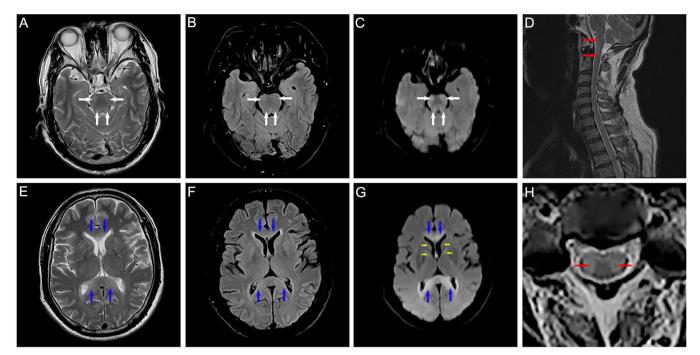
Brain and cervical cord magnetic resonance imaging of a 51-year-old man after approximately 20 days of exposure to tralopyril powder through the respiratory tract. Abnormalities include multiple symmetric hyperintensities of the bilateral periventricular white matter, corpus callosum (blue arrows), basal ganglia (yellow arrow), and brainstem (white arrows) on T2-weighted images and diffusion-weighted images; long segmental patchy hyperintensity in the cervical spinal cord (red arrows) on fat-saturated T2-weighted images; and patchy abnormal signal in the bilateral white matter, hypointensities on T1-weighted images, and hyperintensity on T2-weighted images and T2 FLAIR images. A, D, E, and H are T2-weighted images; B and F are T2 fluid attenuated inversion recovery (FLAIR) images; C and G are diffusion-weighted images.
